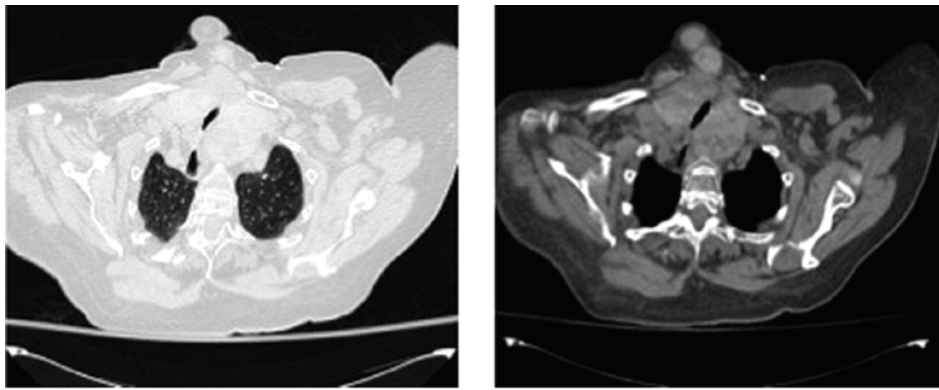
Axial computed tomography with a contrast agent in the mediastinal window (right) and in the parenchymal window (left). It shows a multinodular goiter in the mediastinum with severe compression of the tracheal lumen and a marked reduction in size and deformation of the trachea is observed.
